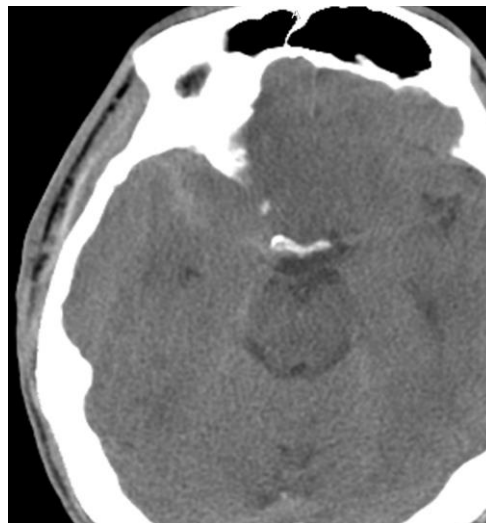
The non-contrast CT scan revealed subarachnoid hemorrhage involving the right temporal lobe and Sylvian fissure.
